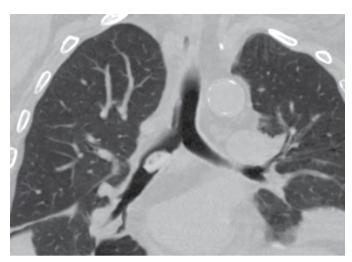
Computed tomography scan showing blister pack in the right main bronchus.
